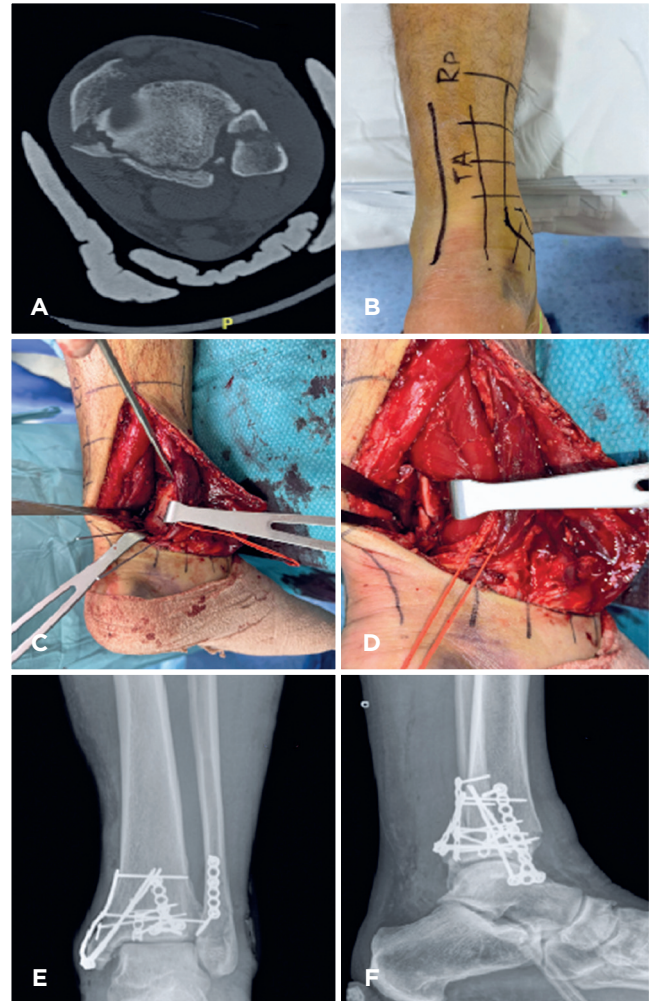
Technique used for the reduction and fixation of the trimalleolar fracture through the single modified posteromedial approach. (A) Axial computed tomography scan of all fracture components involving the posterior, medial, and lateral malleolus; (B) Preoperative skin marking; (C) Provisional fixation of the posteromedial fragment with K wires. Observe the interval between FHL and NVB; (D) Exposure of fibula fracture. Peroneal tendons are retracted laterally and FHL medially; (E-F) Final radiograph images. A buttress plate was applied to the lateral posterior malleolar fractures. The medial malleolus was fixated with an anti-gliding plate and two bicortical screws placed from the anteromedial to the posterolateral direction.
